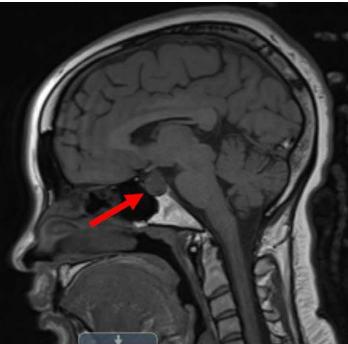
A sagittal view of this patient's second MRI with (upper image) and without (lower image) contrast, where in the 1.7cm pituitary adenoma can be seen (red arrow).
